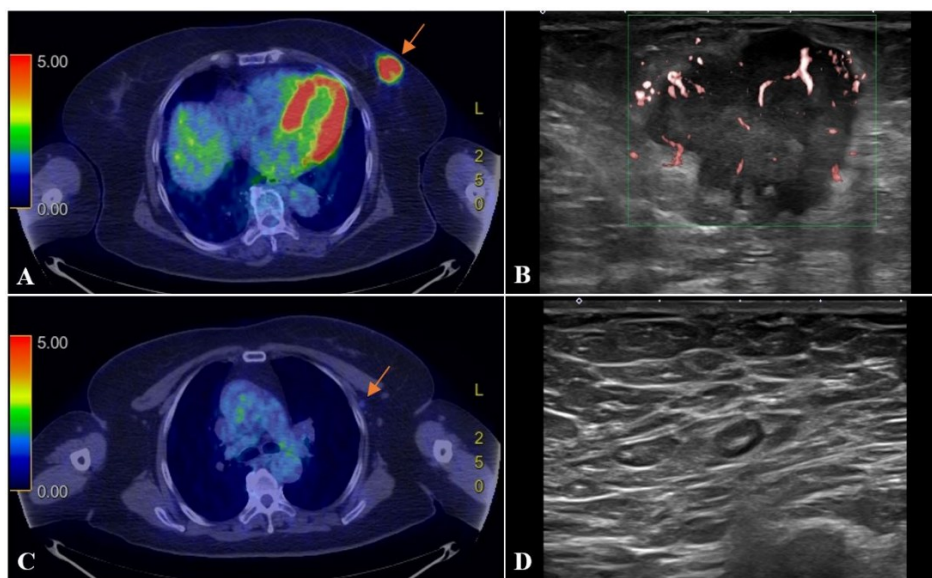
[^{18}F]FDG PET/CT reveals a hypermetabolic tumor (SUVmax of 9.0) in the left lower outer breast (A), along with a lymph node showing faint uptake (SUVmax of 1.1) in the left axilla (C). USG shows a breast tumor with malignant features (B) and an indeterminate axillary lymph node with mild cortical thickening (D)
